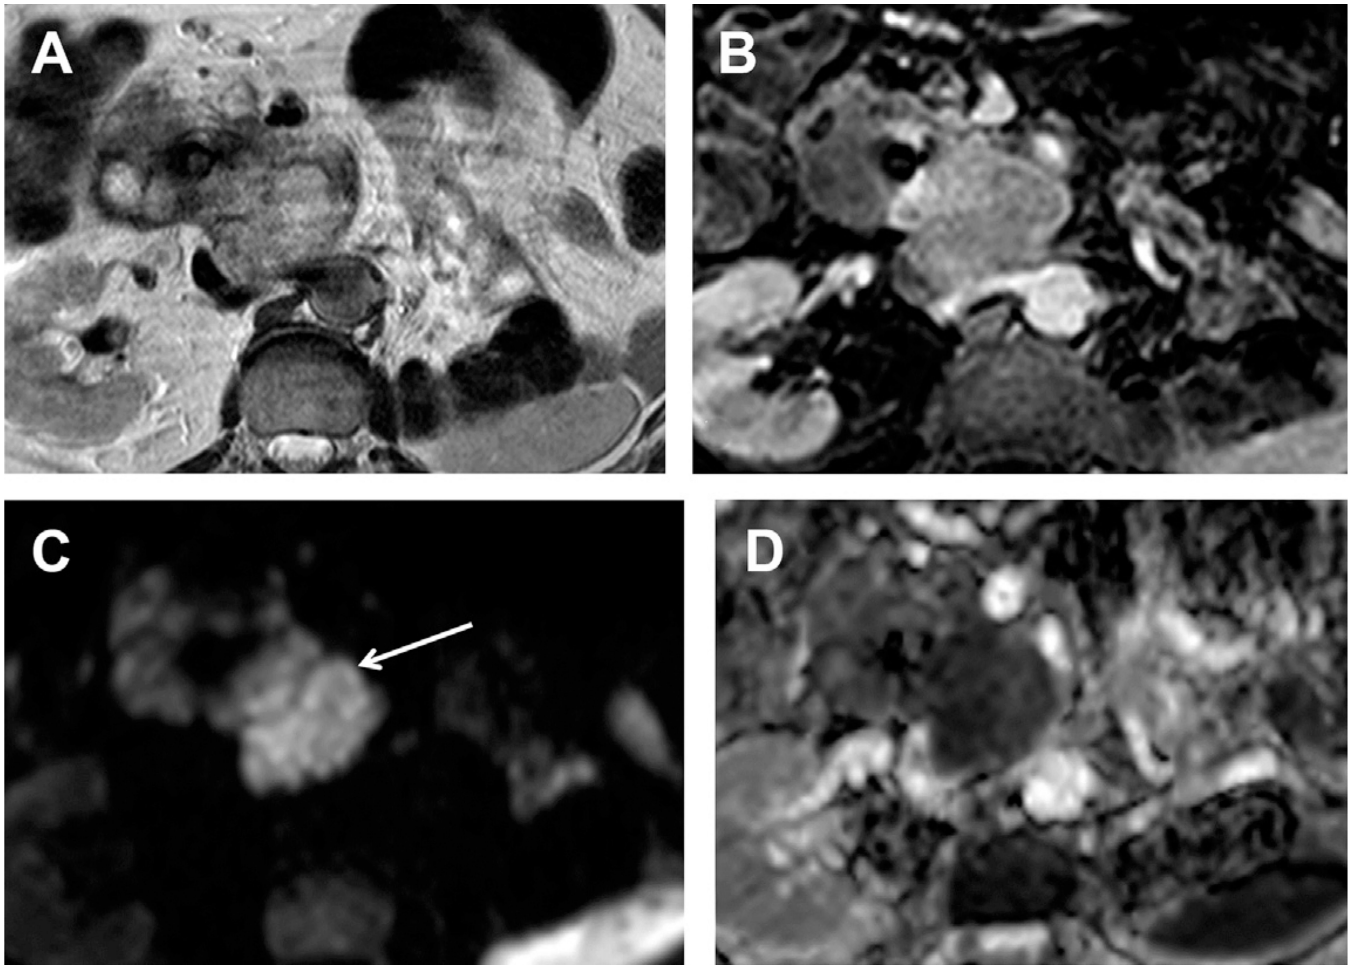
PNET. (A) Axial TSE T2-weighted and (B) postcontrast e-THRIVE during the arterial phase demonstrate a large mass in pancreatic head with vessel involvement. The mass shows high SI on T2-weighted image and intense heterogeneous enhancement. (C, D) DWI with b value of 800 s/mm^2 (arrow) and corresponding ADC map confirm the aggressiveness of the lesion with intense restriction of water motion (ADC: $1 \times 10^{-3} \text{ mm}^2/\text{s}$).
